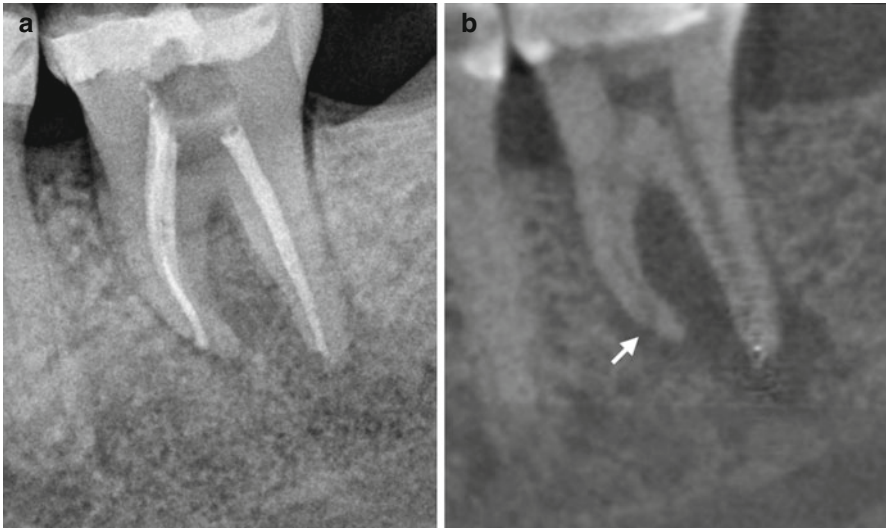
Post-endodontic periapical radiograph of a left mandibular second molar demonstrating a coronally position apical foramen on the mesial root mimicking mismanaged canal instrumentation in the apical third (a). The preoperative sagittal CBCT slice demonstrates a coronally positioned apical foramen (*arrow*) in relation to the anatomic root apex verifying appropriate canal management (b)
